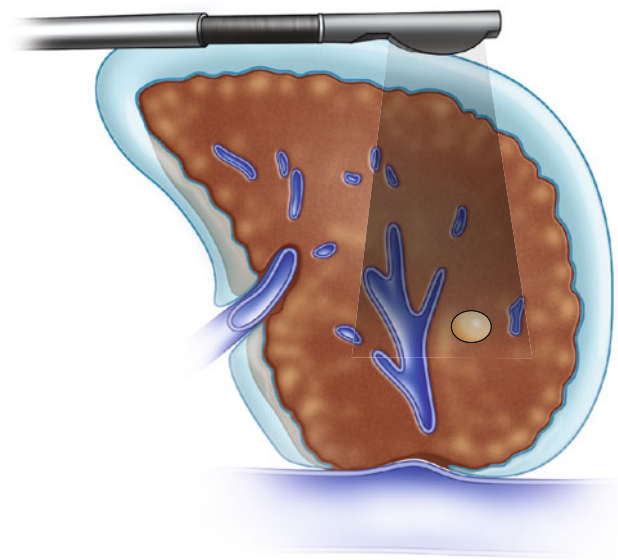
The standoff technique used for a nodular cirrhotic liver using saline as an acoustic window. Ultrasound waves pass through the water layer and into the tissue seamlessly, providing a superior image
